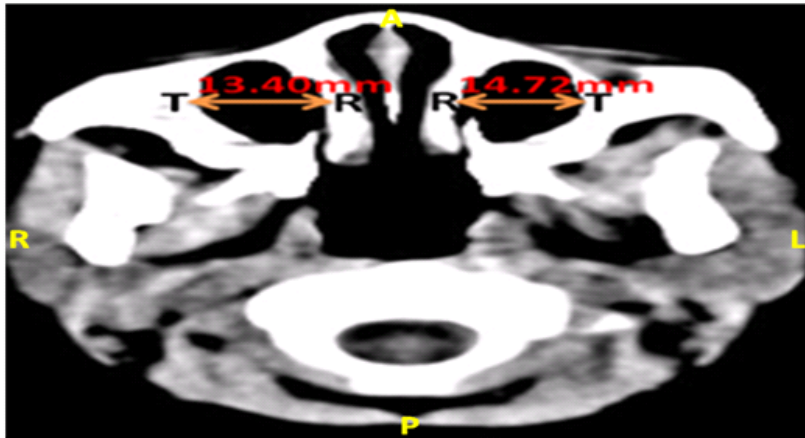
Axial CT of a 27 year Old Female Showing Measurements of the Transverse Diameter (TR). The Right TR is 13.40mm, while TR on the Left is 14.72mm. R= Right side, L= Left side, A= Anterior, P= Posterior.
